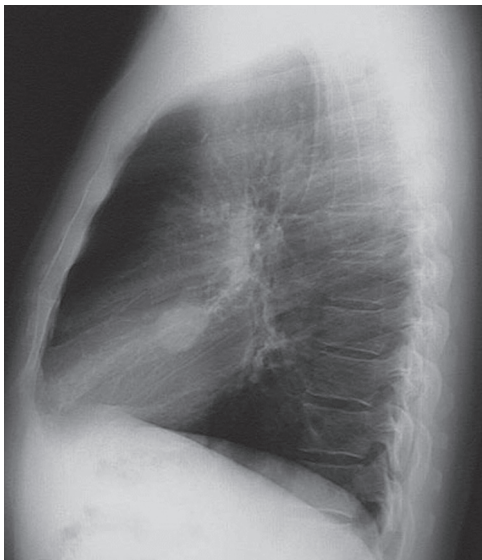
■ Lateral chest radiograph showing a round lesion consistent with a hamartoma.
